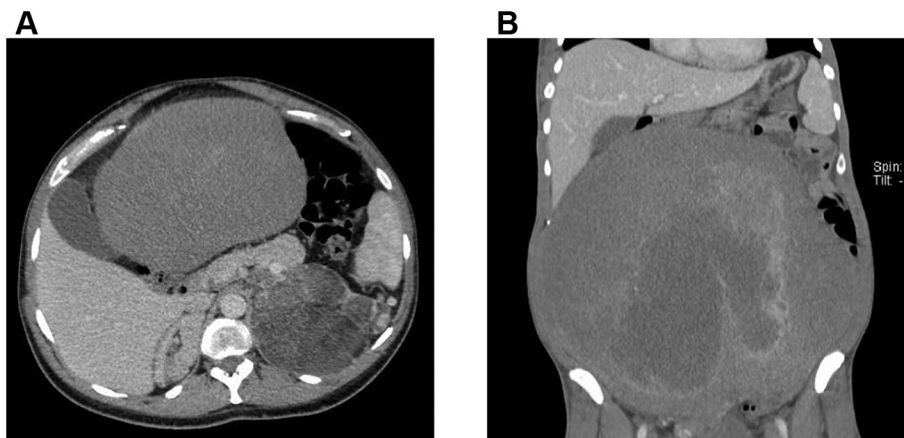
Computed tomography images demonstrating a right adrenal mass (5.9 × 2.4 cm), left adrenal mass (11.8 × 8.8 cm), and large abdominal mass (31 × 35 × 31 cm). A, Axial view of the right adrenal mass, left adrenal mass, and abdominal mass. B, Coronal view of the abdominal mass. The abdominal mass displaces the entire abdomen and nearly all intra-abdominal contents posteriorly. The mass is hypervascular with areas of hypoattenuation and possible internal necrosis.
